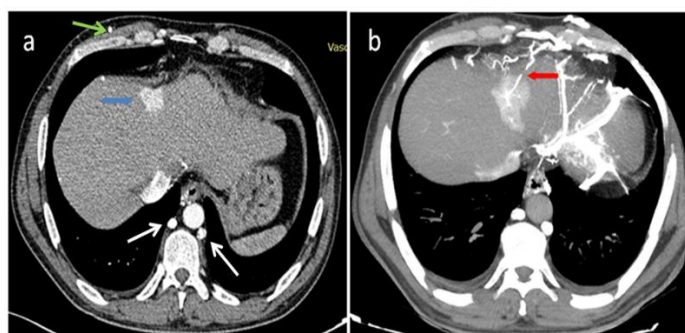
a-Axial arterial-phase-enhanced CT image demonstrating a hypervascular focal enhancement (blue arrow) in segment IVa. Also, note the dilated azygos and hemiazygos veins (white arrows) in addition to cutaneous collaterals (green arrow). b- Axial MIP image shows an enhancing vessel (red arrow) feeding the pseudolesion (Vein of Sappey).
